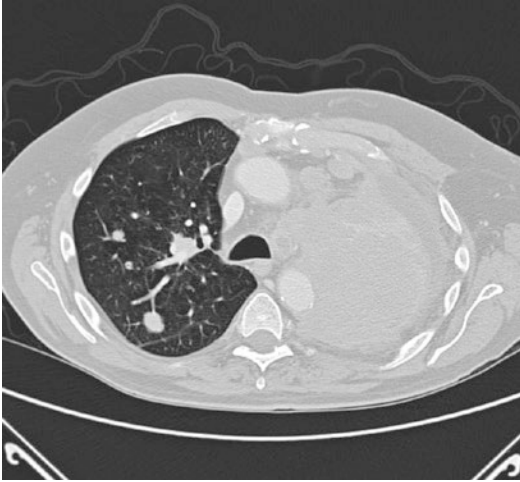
Axial CT section from the same patient as in Fig. 9.3 demonstrates contralateral lung nodules (arrows), which are best visualized with the image displayed using a “lung window”
